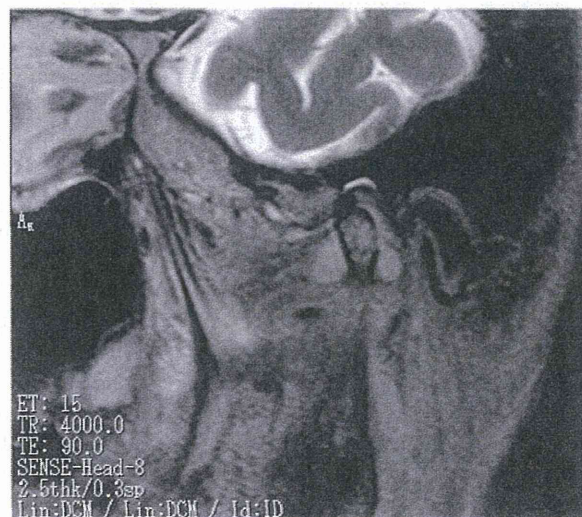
Magnetic resonance imaging showed a collection of intra-articular fluid with upper and lower capsular distension on T2-weighted images.
